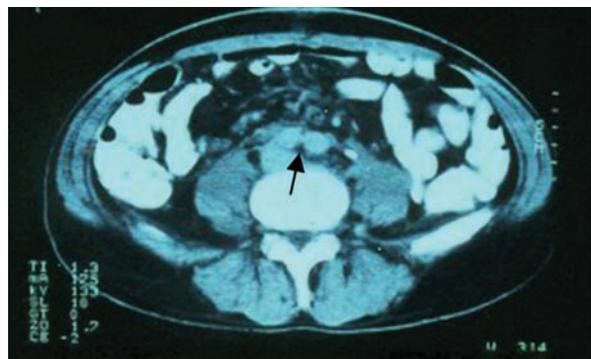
Postoperative CTA after 30 days of operation of AAA, showing the two limbs of the graft.
